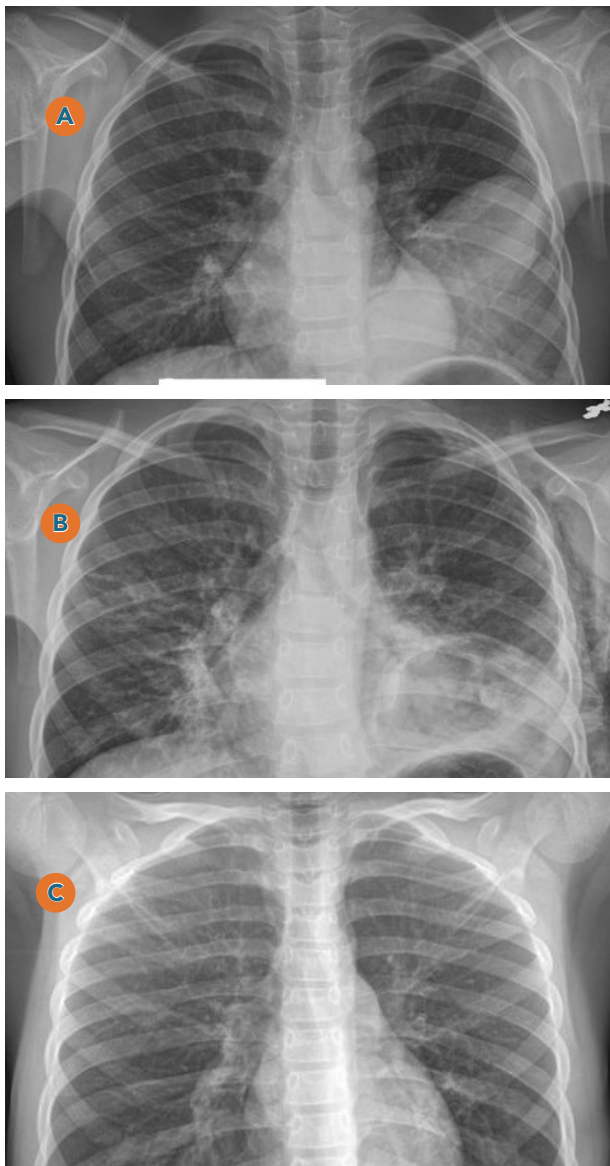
Patient P, 9 years old. A - preoperative chest X-ray: the presence of a large formation in the lower lobe of the left lung; B - chest X-ray 10 days postoperatively: the presence of a residual cavity; C - chest X-ray 60 days postoperatively
